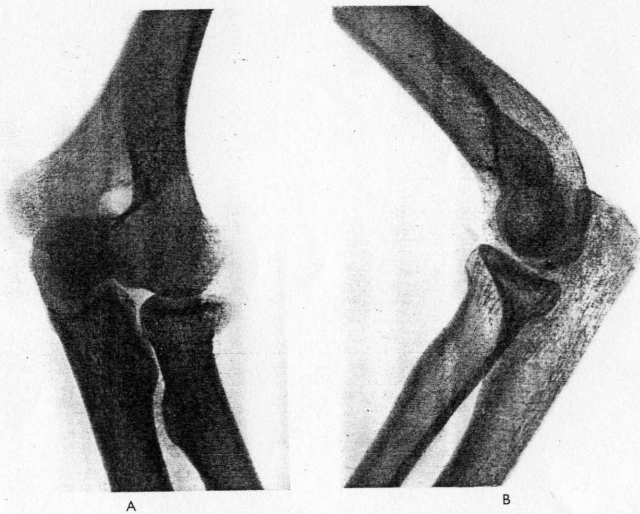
Case V. C. A, The original anteroposterior X-ray picture of a Type 2 fracture of the radial head. The sector fracture is less than one-quarter of the articular circumference, is depressed below the joint surface, and is not tilted. B, The lateral radiograph taken 15 months later. The plateau of the head of the radius is not distorted and the elbow-joint appears normal. Note the 'chip' fracture of the coronoid process visible in both radiographs. The function of the joint was full.
